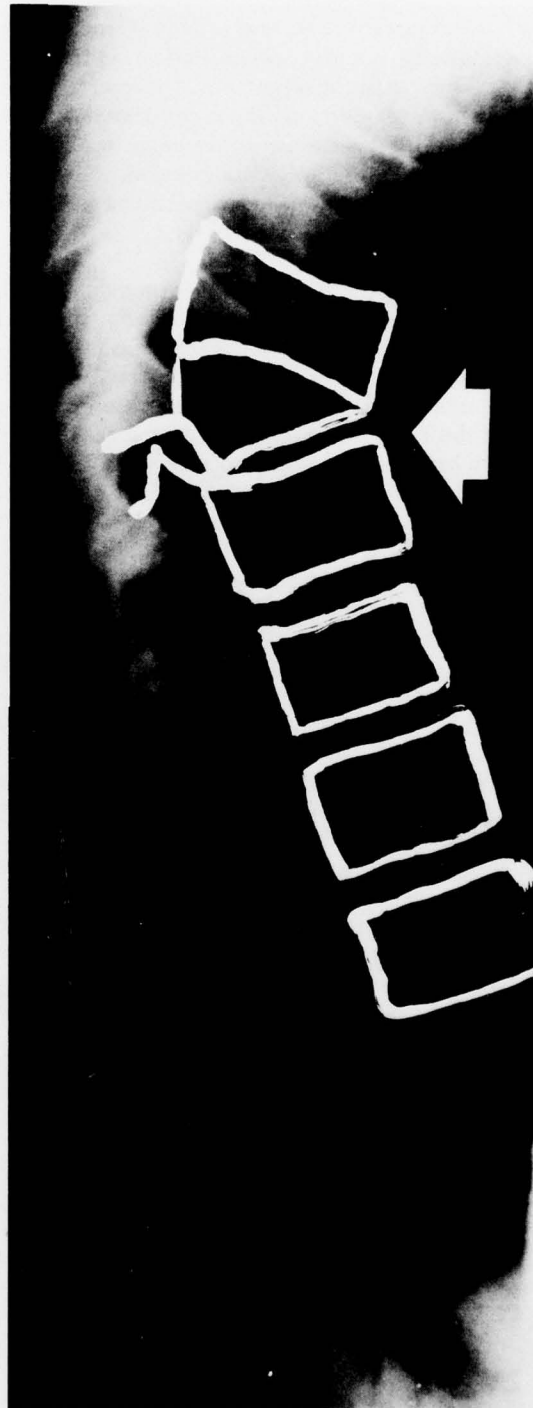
Lateral Roentgenogram of Subject TI 4 Days After Ejection [Arrow Identifies Site of Anterior Wedge Compression Fracture]
